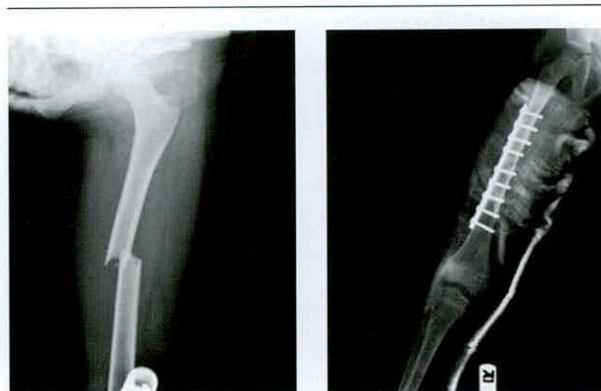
A Pair of Radiographs: Initial Referral and Post-Fixation
